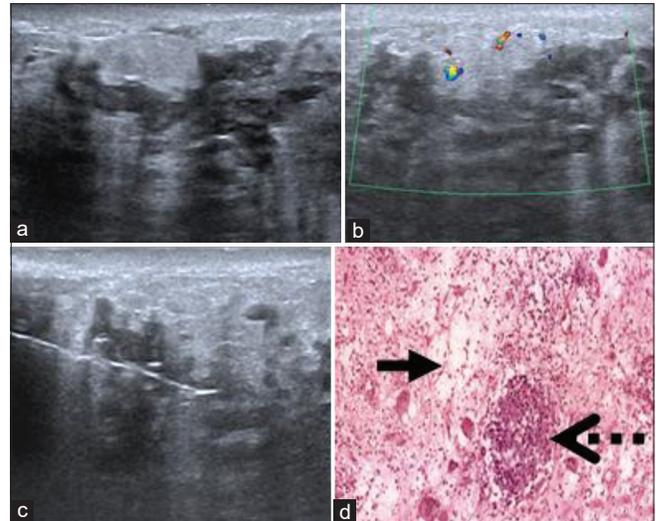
A 31-year-old female with a history of skin changes 1 week and progressive hardness of breast 4 months. (a) Ultrasound image shows multiple dilated ducts with thick internal echoes seen within. (b) Color Doppler image shows vascularity within the adjacent parenchyma- probable diagnosis of idiopathic granulomatous mastitis was made. (c) Ultrasound-guided biopsy of the mass. Multiple biopsy cores were obtained from within and periphery of the abnormal ducts. (d) H & E: Granulomatous lesion (Dotted Arrow) with adjacent fat necrosis (Black Arrow) $\times 200$
